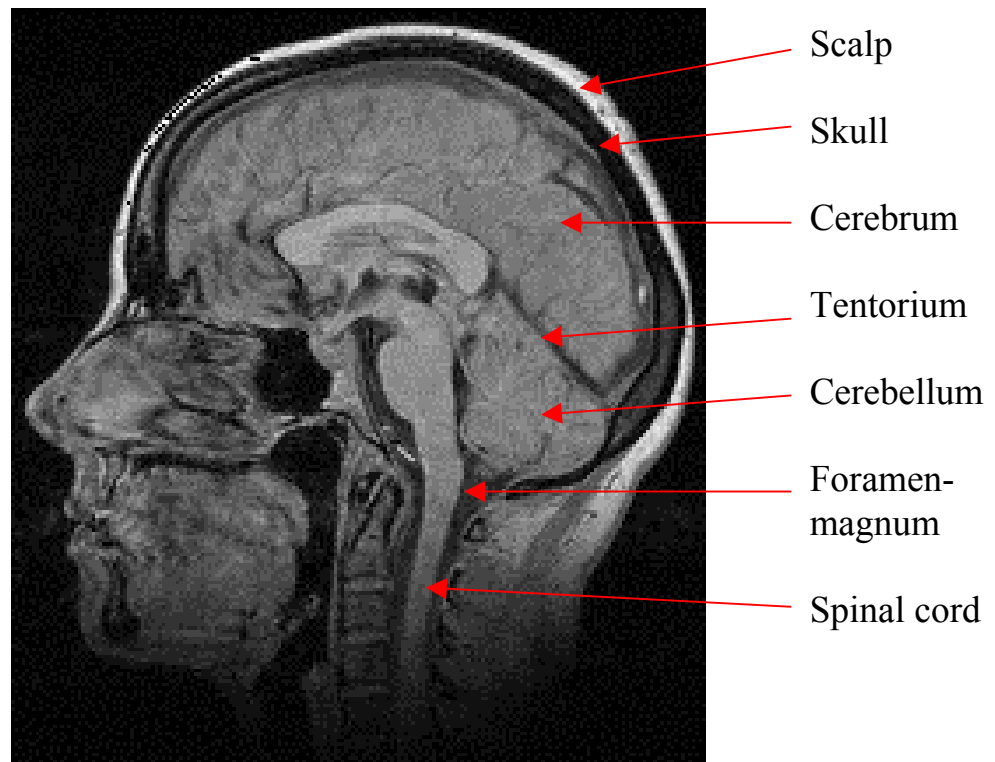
CT scan of a sagittal section of the human head.
